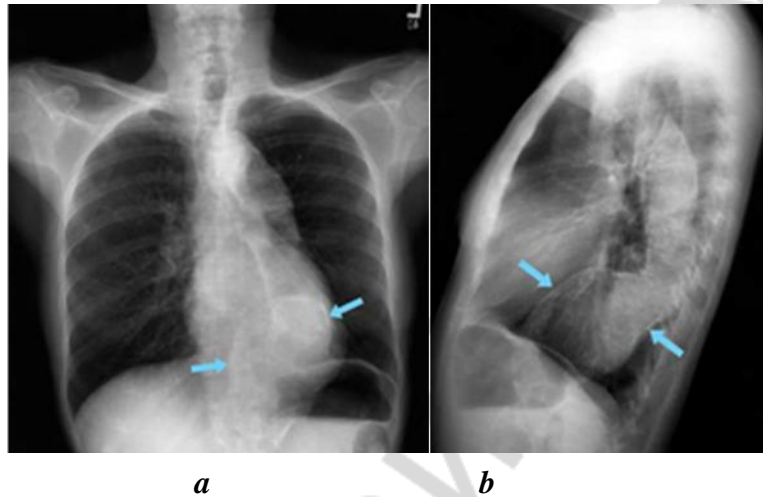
Chest x-ray of a patient with a thoracic aortic aneurysm in direct (*a*) and lateral (*b*) positions
